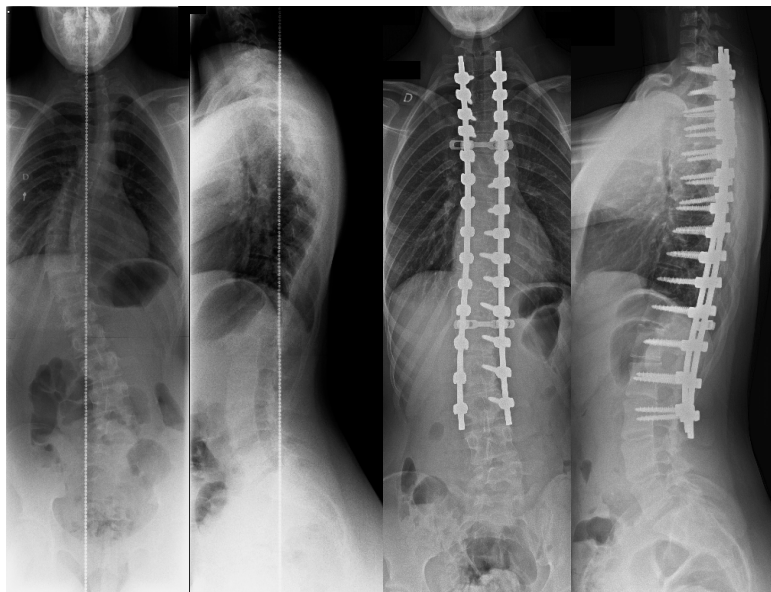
AIS treated with PSI. 3-A to 3-D. 14-year-old girl with adolescent idiopathic scoliosis. Preoperative standing radiographs (A, B) demonstrate 47-degree thoracic scoliosis. Standing radiograph (C, D) at two-year FU demonstrate deformity correction with PSI and fusion.
